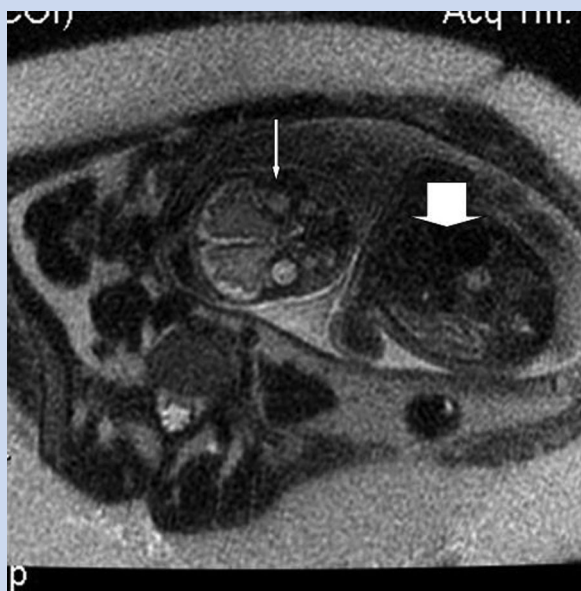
Fetal MRI, 29 weeks gestation, diaphragmatic hernia [wide arrow], left-sided microphthalmia [thin arrow].
